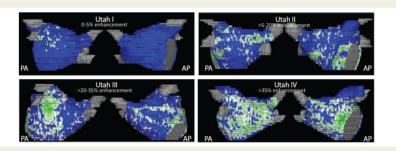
Quantification of left atrial structural remodelling with delayed enhancement magnetic resonance imaging ('Utah I–IV'). Posterioranterior and anterior-posterior view of enhancement (green) vs. normal tissue (blue) in patients with 'Ione' atrial fibrillation (Courtesy of Nassir F. Marrouche, M.D., CARMA Center, Sat Lake City).
